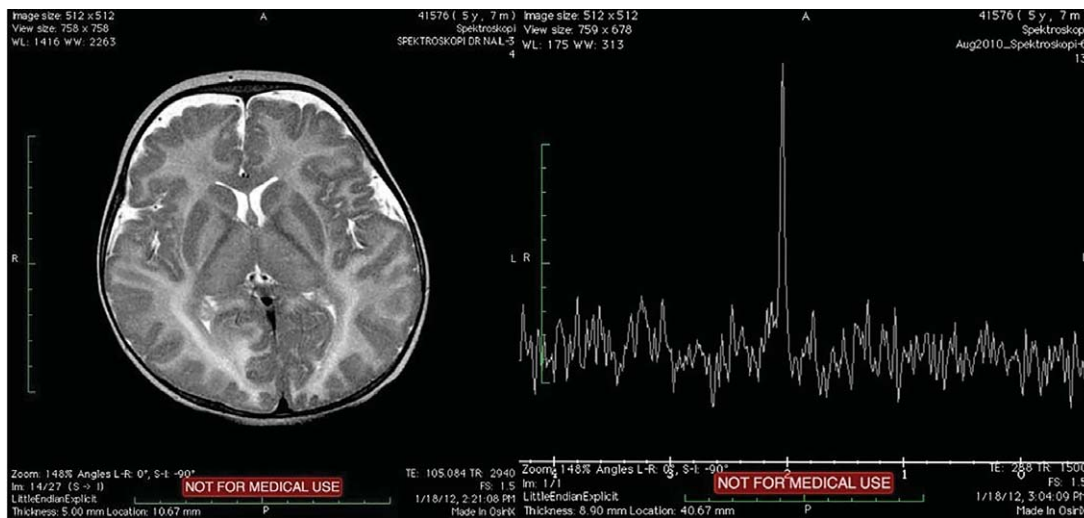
MRI demonstrating delayed myelinization at corpus collosum, capsula interna genu, and posterior limb. Hyperintensity of both globus pallidus, thalamus, dorsal aspect of brain stem, corticospinal tractus, and cerebellum. MRS demonstrating a prominent NAA (N-aspartyl aspartate) peak on posterior deep white matter lobe.
